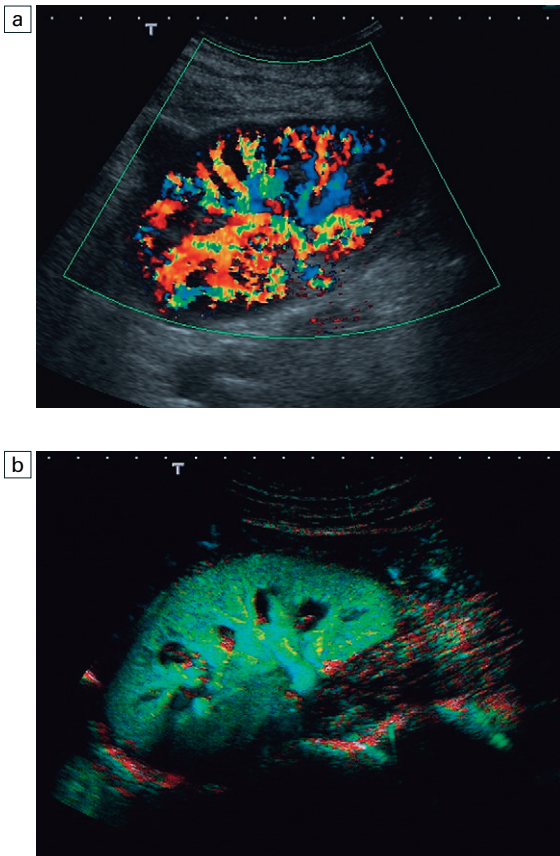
(a) Colour flow Doppler demonstrating enhancement of the colour signal within the intrarenal vessels after the injection of contrast. (b) Pulse inversion harmonic image in bubble destruction reperfusion mode demonstrating parenchymal perfusion.
